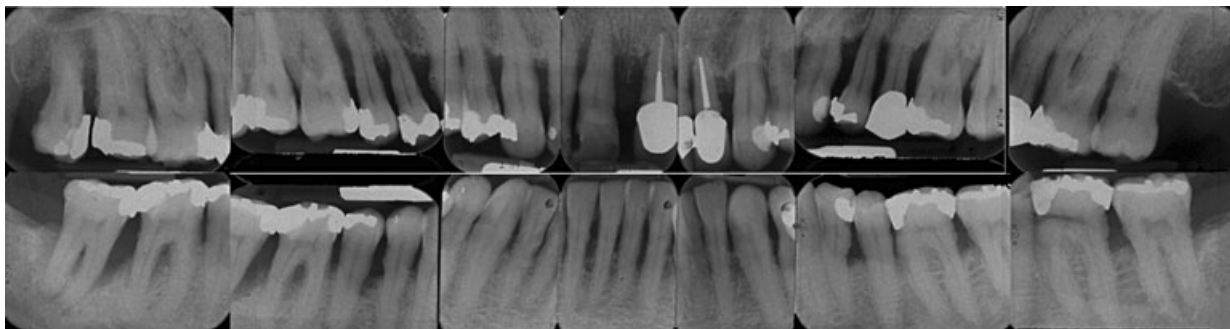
Periapical radiographs of the patient presented in Fig. 26-1.
